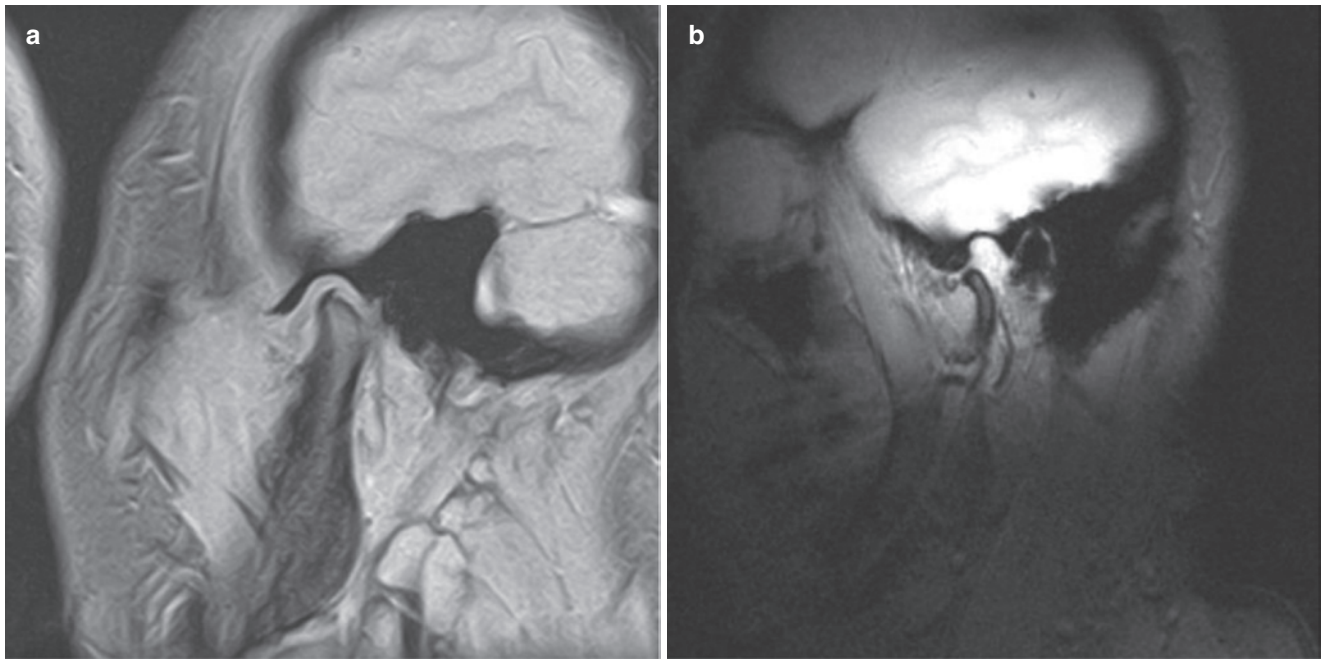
(a) TMJ MRI in closed mouth view with anterior disc displacement. (b) TMJ MRI in open mouth views with anterior disc displacement without reduction
